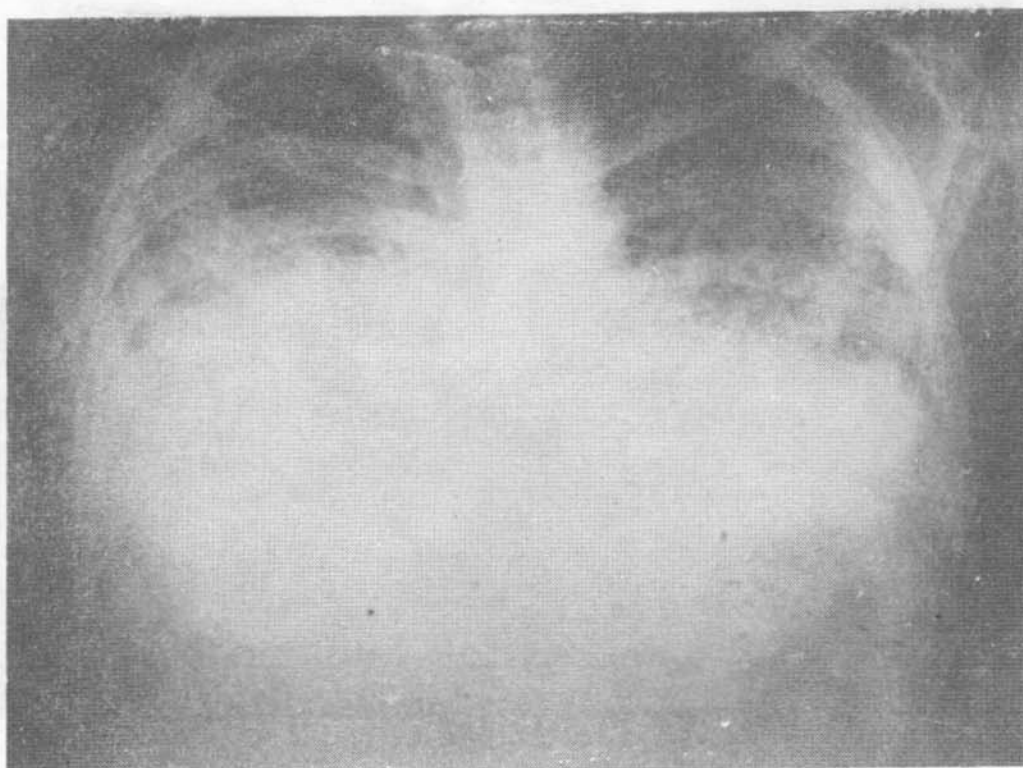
X-ray of sibling showing diffuse bilateral opacities.
